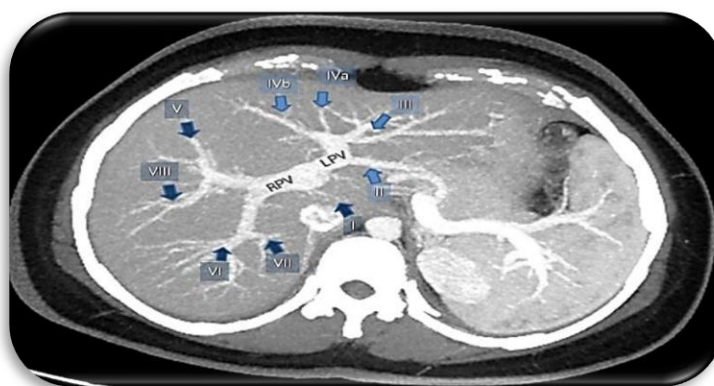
CT Showing segment of the liver. (*Oliveira et al.,2011*)
